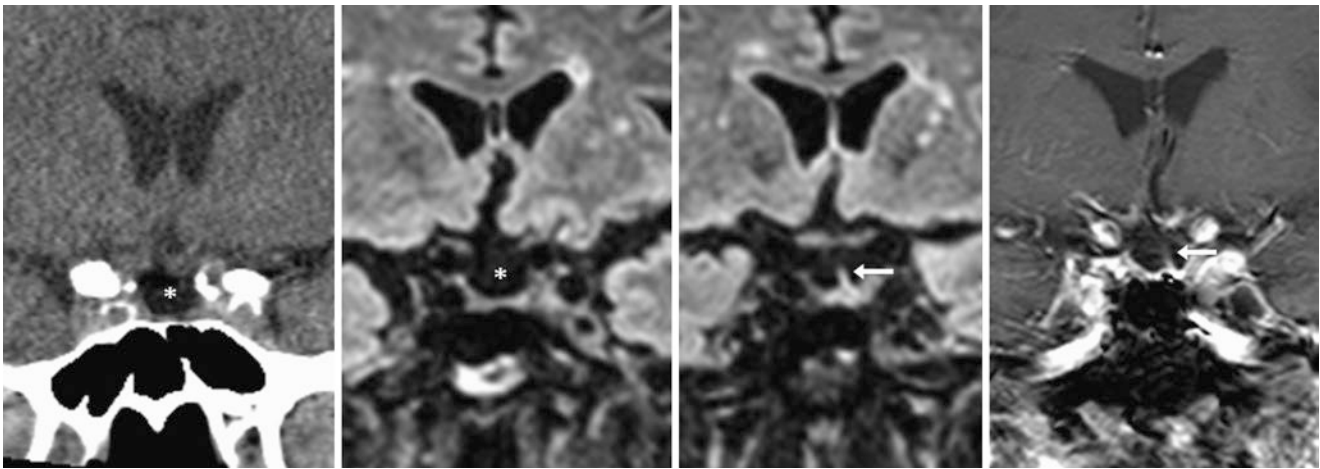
An 80-year-old female had a 3 T MRI performed for stroke symptoms (interpreted as negative) and an incidental partial form of PES (*) on NECT coronal reformats (*left*) and on coronal FLAIR
